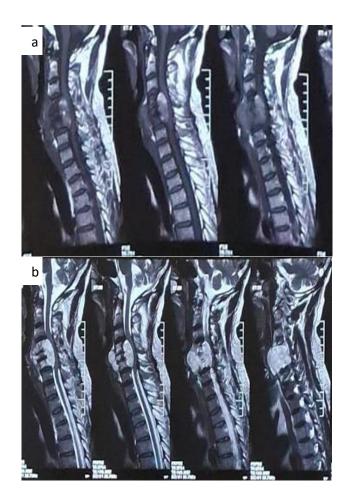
MRI cervical spine T1 and T2 weighted image sagittal view.
